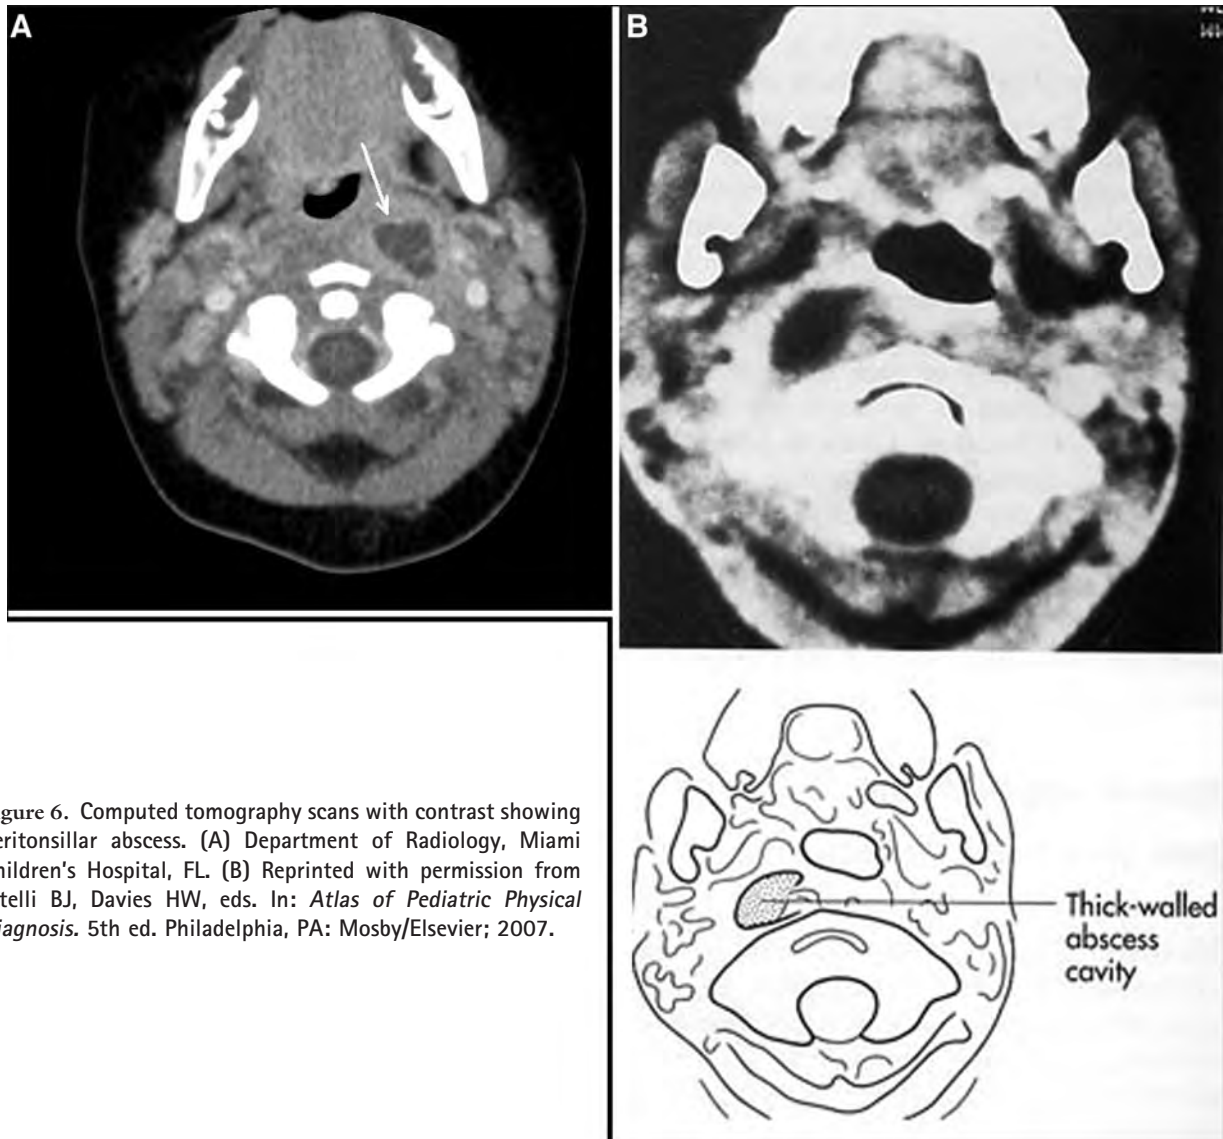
Computed tomography scans with contrast showing peritonsillar abscess. (A) Department of Radiology, Miami Children's Hospital, FL. (B) Reprinted with permission from Zitelli BJ, Davies HW, eds. In: *Atlas of Pediatric Physical Diagnosis*. 5th ed. Philadelphia, PA: Mosby/Elsevier; 2007.
